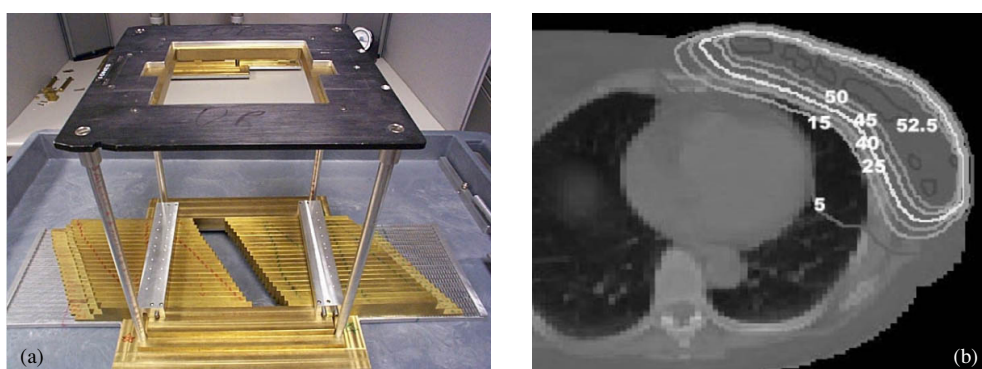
(a) View of prototype electron multi-leaf collimator (from Hogstrom *et al* (2004)). (b) Intact breast treatment plan using eight-field modulated electron radiation therapy, which spares normal tissue better than standard x-ray and IMXT treatment plans. Isodoses are in units of Gy (redrawn from Ma *et al* (2003)).
